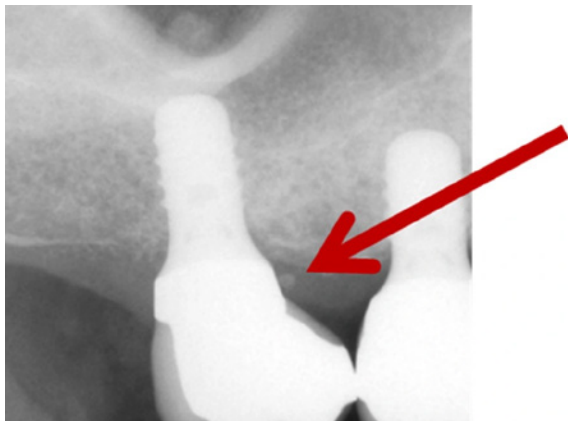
Peri-implantitis lesion (radiographic view).
